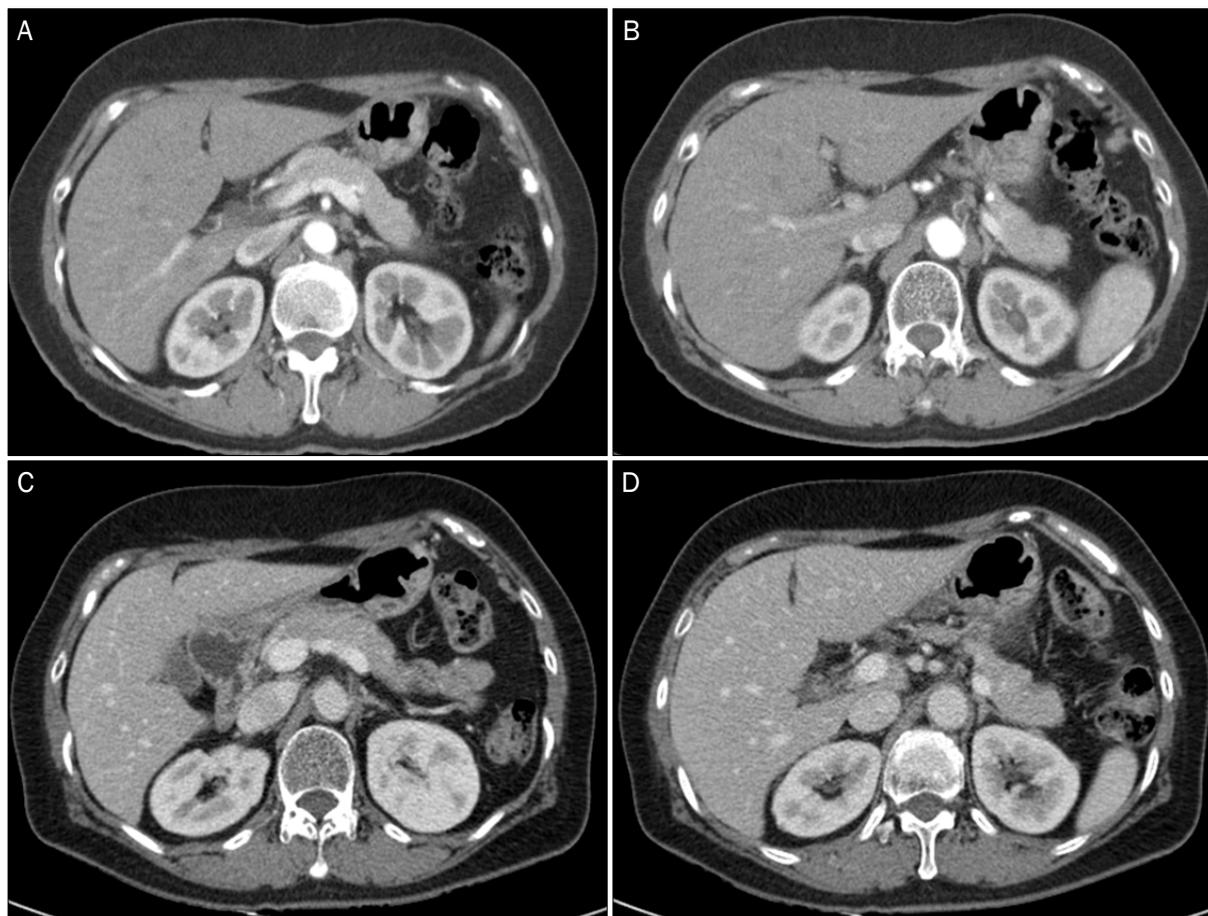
Axial contrast-enhanced abdominal computed tomography image showing no evidence of abnormal lesions and a normal pancreatic duct (A, B, arterial phase; C, D, delayed phase).
